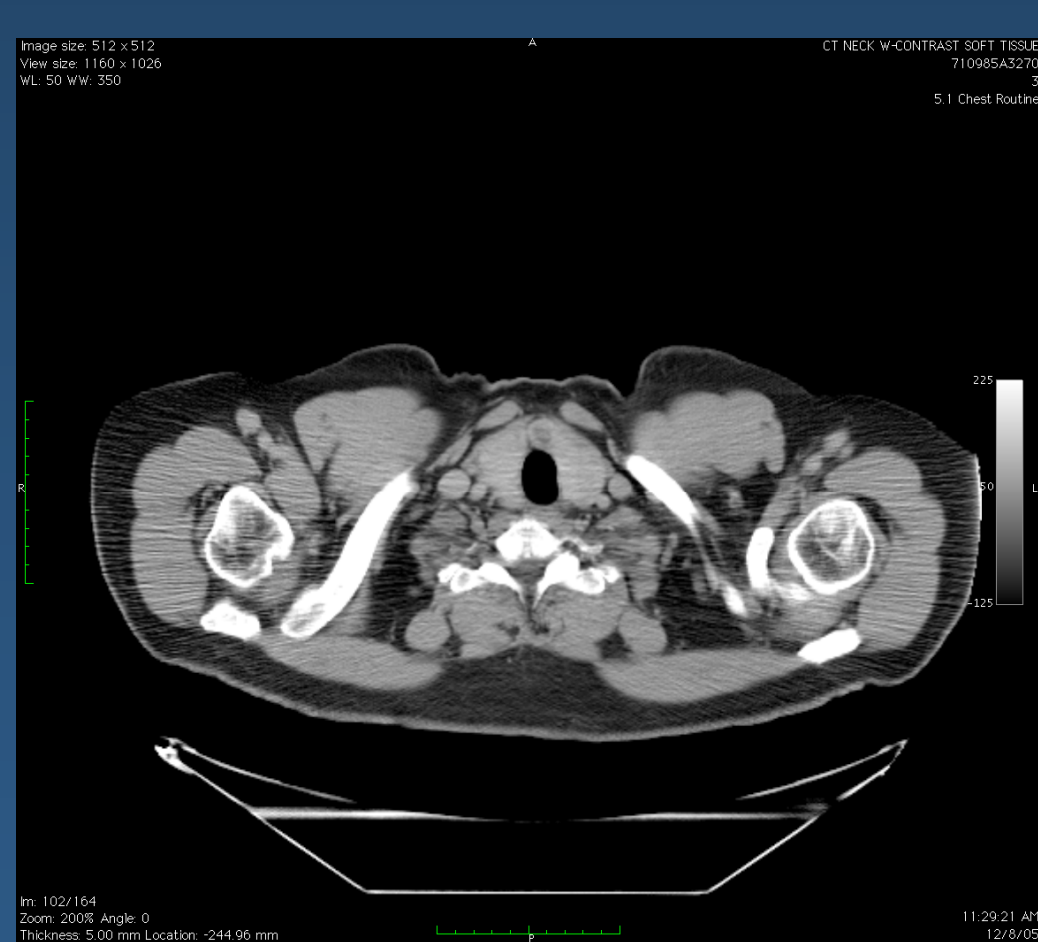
Preoperative CT scan axial image of patient 1, goiter and mild tracheal compression (Preop AHI 56).
